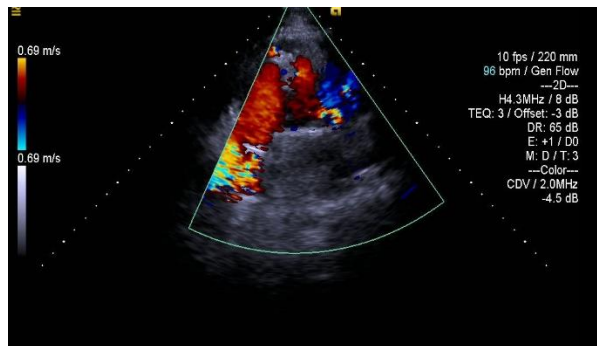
The 2D echocardiography with color flow mapping, in the parasternal short-axis view, demonstrates abnormal flow within the left coronary artery toward the main pulmonary artery.
